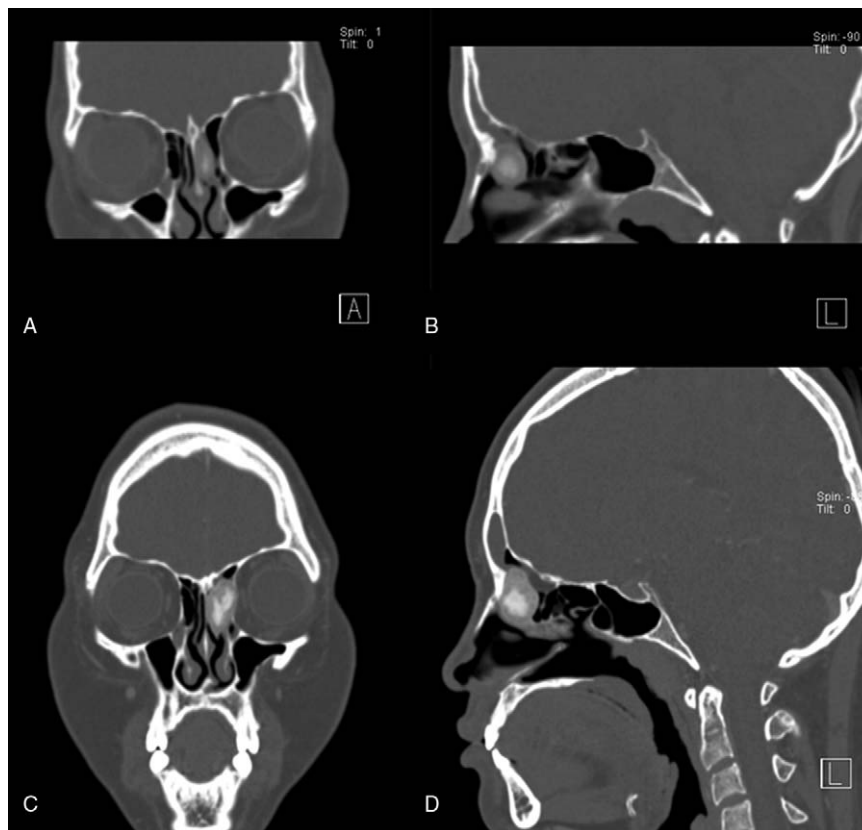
A, B, In our first case, coronal and sagittal CT 6 years previously showed a relatively small ($0.8 \times 2 \times 1.6$ cm) lesion in the middle turbinate with ground glass appearance and with a sclerotic rim. C, D, Six years later, coronal and sagittal CT showed a $1.4 \times 2.6 \times 1.7$ cm lesion in the middle turbinate with a heterogenous appearance containing mottled calcification and soft tissue.
